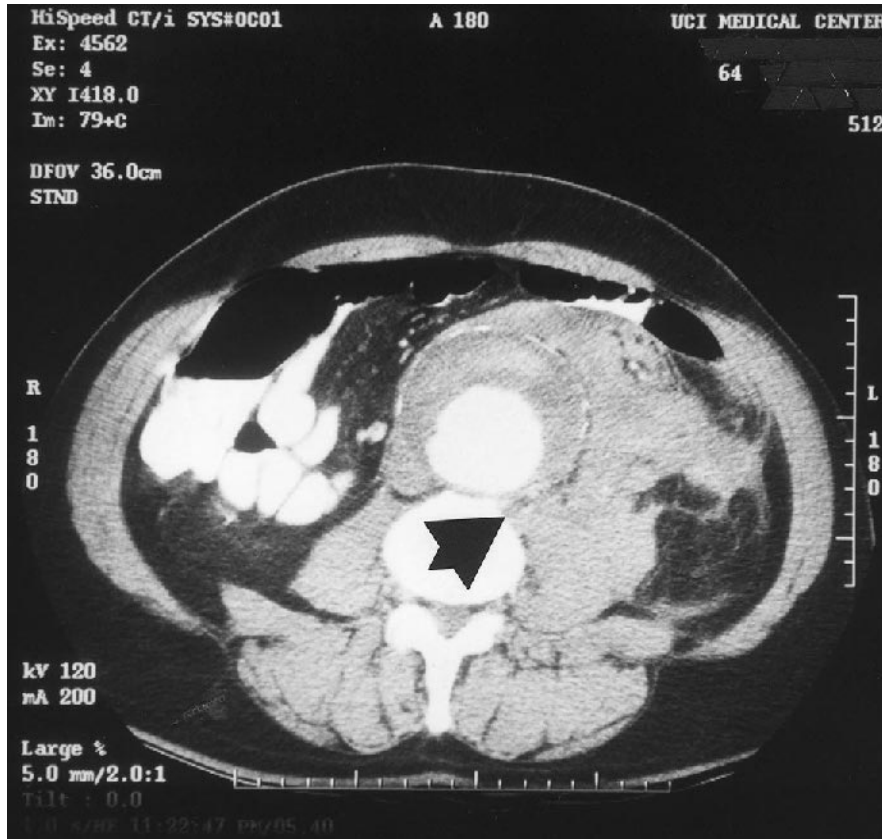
CT scan demonstrates a contained rupture of an 8-cm infrarenal abdominal aortic aneurysm. Note extravasation of blood into surrounding left retroperitoneum and small bowel mesentery.
